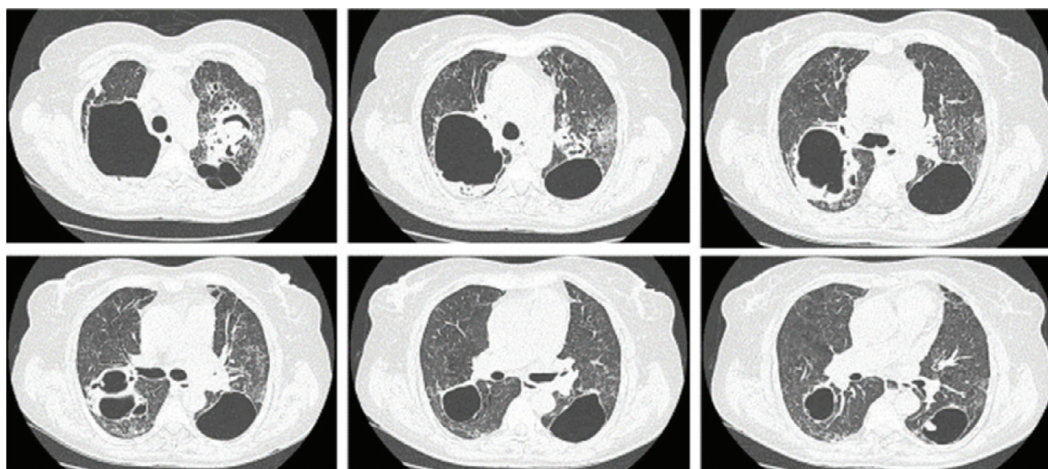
Results of computed tomography of the patient's chest 19.05.2022
